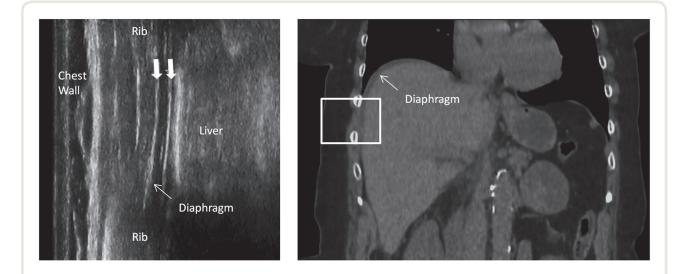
Example of ultrasound visualization of the diaphragm at the zone of apposition (left panel) and comparative computed tomography scan (right panel). The diaphragm could be identified as the hypoechogenic zone bounded by the two hyperechogenic pleural and peritoneal layers (*parallel arrows* in the left panel).
